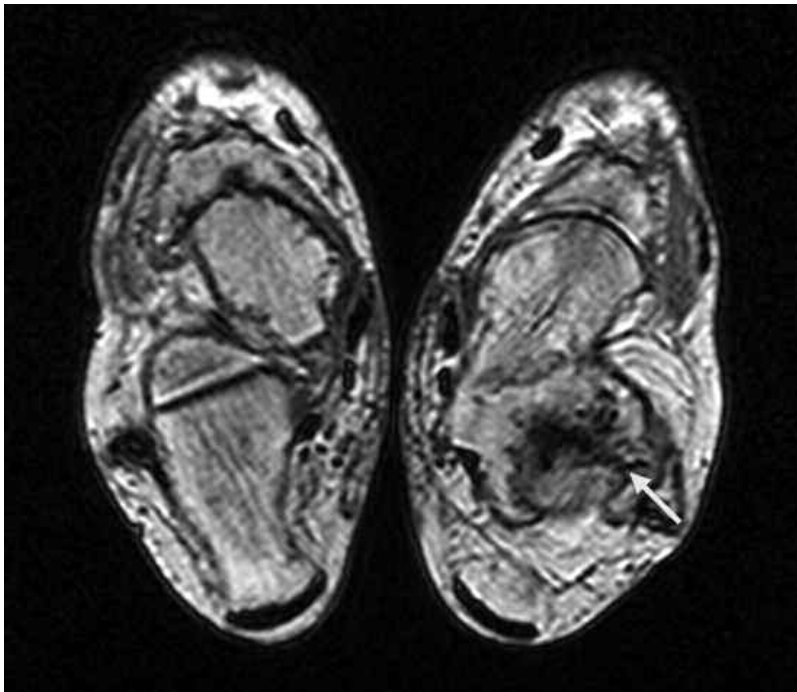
T1-weighted axial image showing extensive erosions in the right ankle (arrow).
